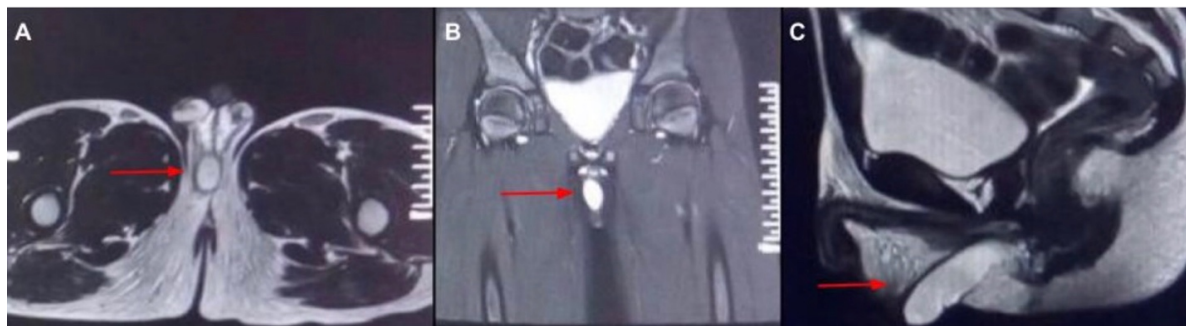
MRI low T1 and high T2 signal intensity of the perineal cyst. (A) transverse, (B) coronal and (C) sagittal MRI cross sections showing perineal midline, with right inclination cyst which is unilocular and thin walled, extending from the root of penis to the perineum with homogenous T1 and T2 intensity.
